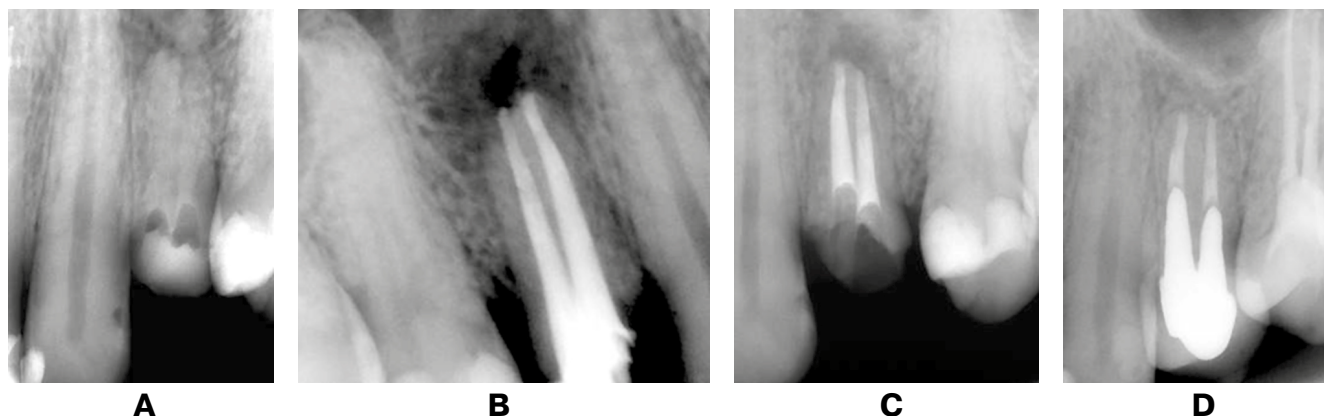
Periapical radiograph of tooth 2.4: *A* – an area of bone rarefaction with ill-defined, irregular borders is noted in the periapical region of tooth; *B* – the root filling is homogeneous, with no extrusion of filling material beyond the apices of tooth; *C* – six months after endodontic treatment (interim follow-up), the radiograph clearly shows a reduction in the periapical bone destruction lesion, the tooth is being prepared for prosthetic restoration; *D* – twelve months after endodontic treatment (follow-up examination), the radiograph shows complete healing of the periapical bone destruction lesion, full prosthetic rehabilitation of tooth has been completed
